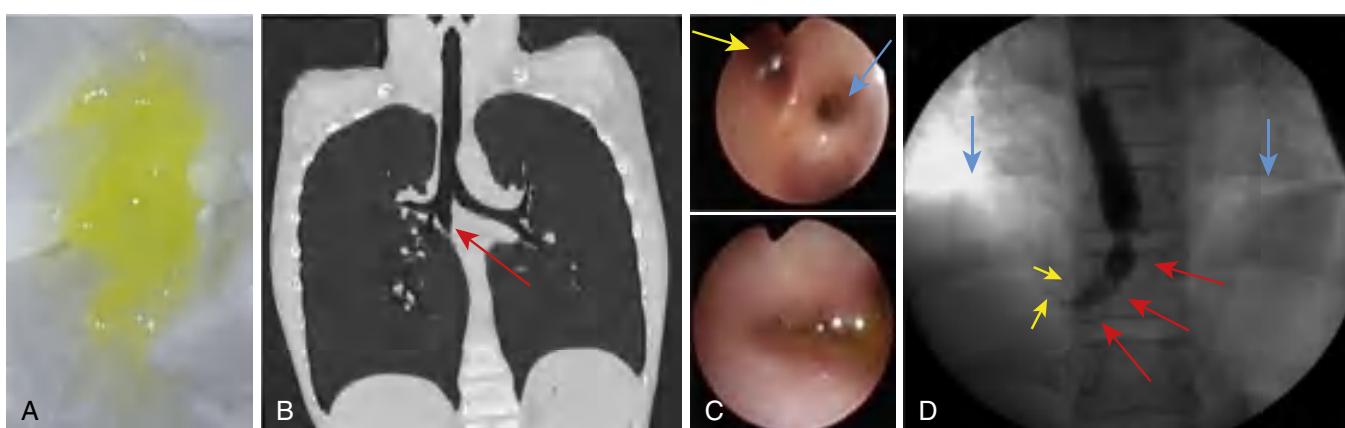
Bronchobiliary fistula. A, Unusually bright yellow, serous sputum was observed. The sputum differed in appearance from the yellow sputum containing leukocytes associated with infections. B, CT scan revealed an abnormal bronchial bifurcation originating in the right main bronchus and extending downward (arrow). C (Top), Bronchoscopic images of the right second carina revealed an anomalous orifice (yellow arrow) in the medial side of the right intermediate bronchus (blue arrow). (Bottom), Close-up photo of the abnormal orifice with yellow, serous secretion. D, Fistulography with a balloon catheter revealed contrast material slowly proceeding through the intraabdominal region (red arrows) to the intrahepatic region (yellow arrows) below the diaphragm (blue arrow). (From Shimizu A, Otani Y, Ishitate M. Congenital bronchobiliary fistula with bright yellow serous sputum. J Pediatr. 2020;243:235–236, Fig. 1.)
